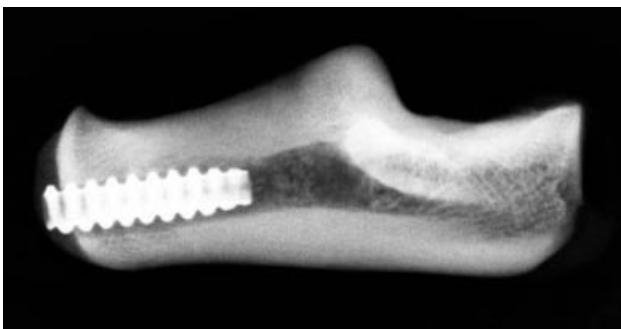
A pre-testing lateral radiograph of the calcaneus showing the interference screw and radiolucent implant *in situ*.
